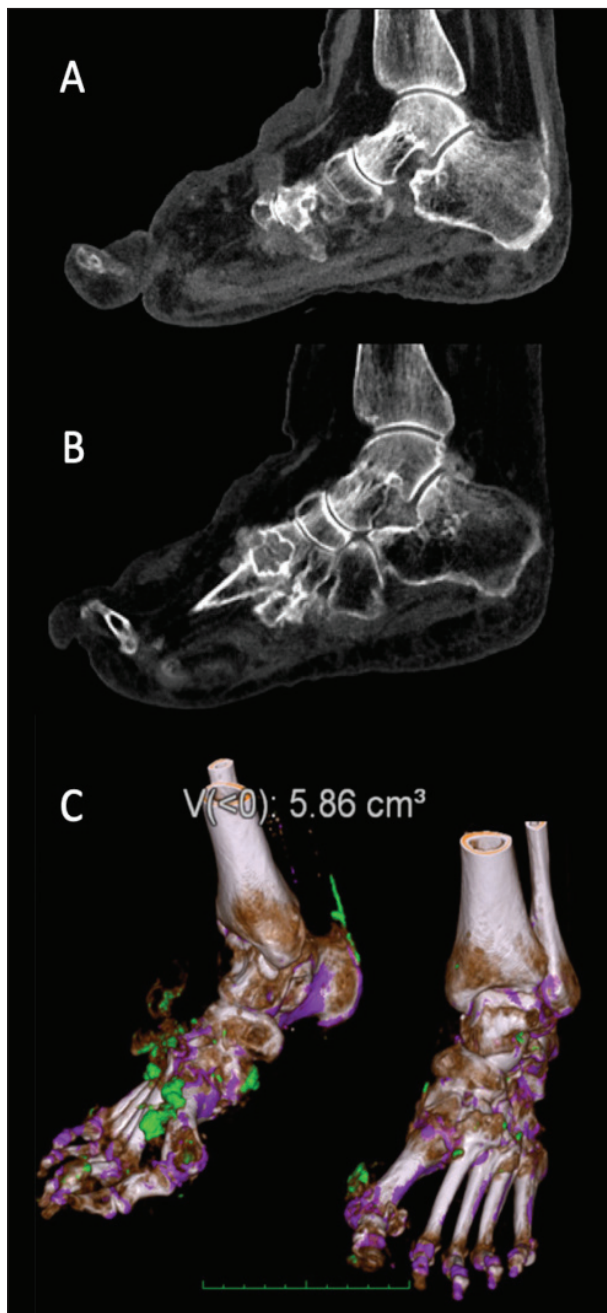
Dual-energy CT. A-B: sagittal multiplanar reformatted grayscale images of ankles/feet showing large bone erosions and severe joint damage at the tarso-metatarsal joints of both feet, with high-attenuating material adjacent to the erosions and along the distal end of the right Achilles tendon (A) representing monosodium urate deposition. C: corresponding volume-rendered color-coded dual-energy image of ankles/feet showing urate deposits (depicted in green) at the tarsometatarsal, metatarsophalangeal and interphalangeal joints and along the distal end of the right Achilles tendon. Automated quantification of urate volume is displayed at the top of the image.
